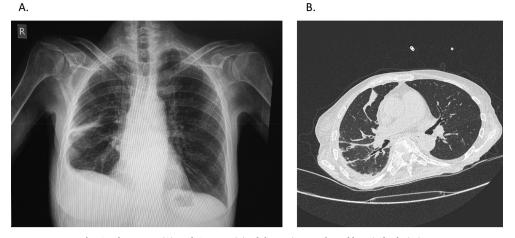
Chest X-ray(A) and CT scan (B) of the patient at day of hospital admission.
